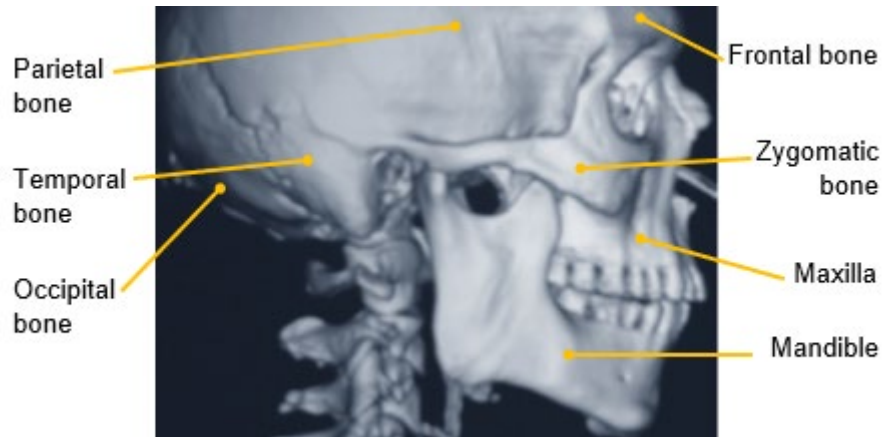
CT reconstruction of the skull. Right lateral view.
